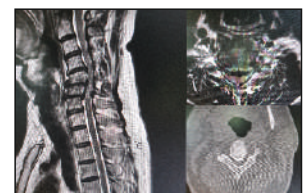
Showing CT as a useful investigation for identifying ossification of PLL (red arrow)
